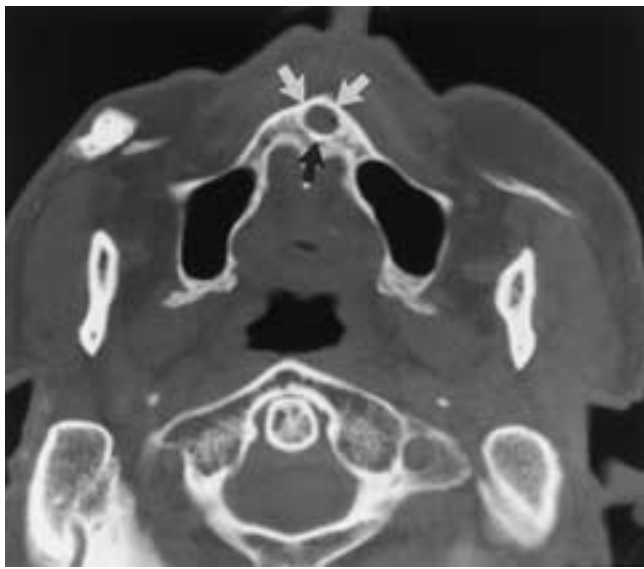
Incisive foramen cyst. Axial CT scan demonstrates an incisive foramen cyst. It is a benign-appearing, well-corticated lesion (*arrows*).
